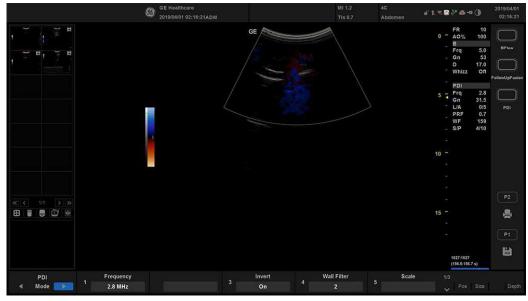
Power Doppler Imaging screen -- Representative Example
